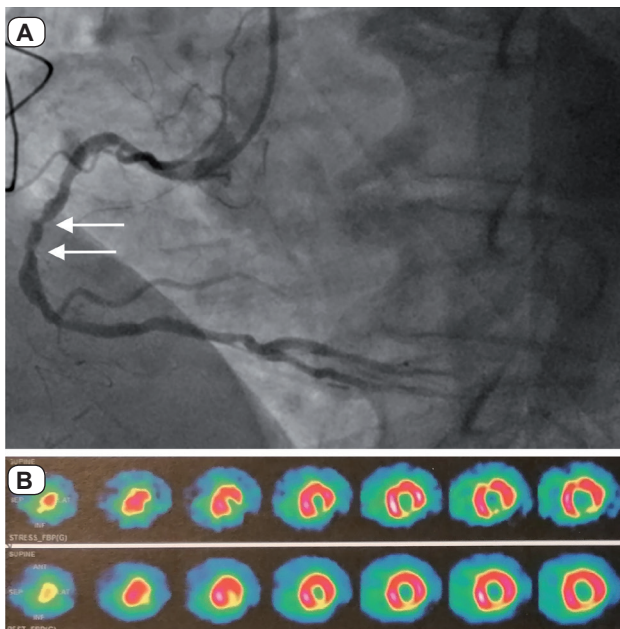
Coronary angiogram of right coronary artery (A). White arrows show moderate stenosis of the middle part of the right coronary artery. Myocardial perfusion scintigraphy (B) shows reversible perfusion defect during stress phase in the inferior wall area confirming significant stenosis in the middle part of the right coronary artery.
